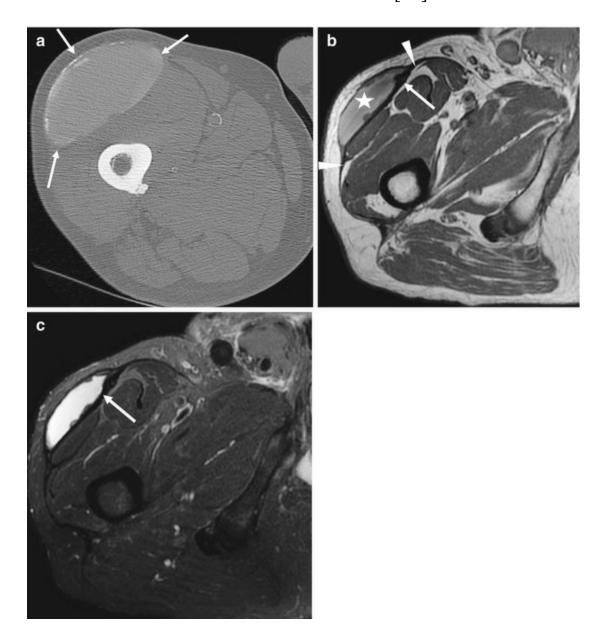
A 70-year-old man with a history of major trauma 30 years ago, evaluated for a partially calcified mass incidentally discovered on a pelvic radiograph (not shown). (a) Axial CT image demonstrates a bi-concave, superficial, spontaneously hyperdense mass at the proximal thigh (*arrows*). Note that the lesion is located at the level of the deep aponeurosis of the thigh (fascia lata) and that it presents a peripheral rim of calcifications. Axial (b) T1- and (c) fat-suppressed T2-weighted MRI confirm the location of the mass adjacent to the fascia lata (*arrowheads*). The lesion is spontaneously hyperintense on T1 (*star*) and presents a thick low-signal intensity capsule in both sequences (*arrow*). These findings confirm the diagnosis of a chronic Morel Lavallée lesion of the proximal thigh
